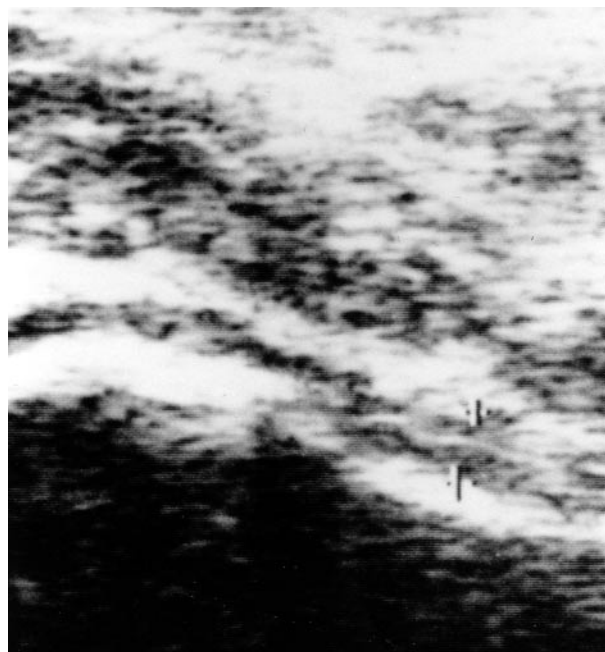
Ultrasonography of a normal hip joint. The 2 markers show the distance between femoral neck (lower mark) and joint capsule (upper mark), which was 0.42 cm.
